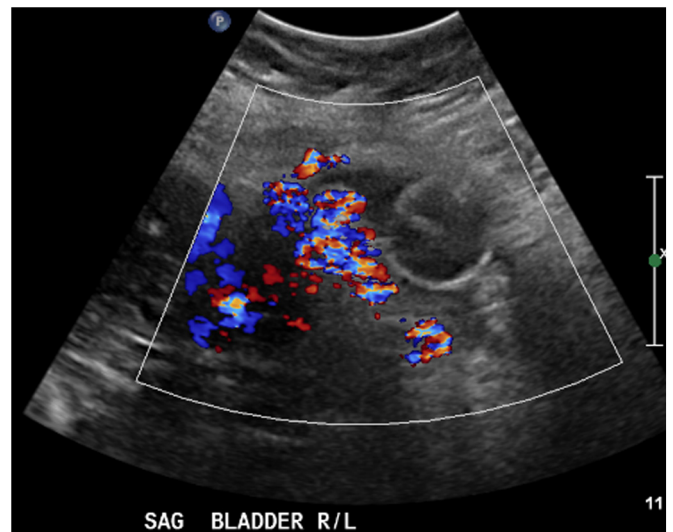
Color Doppler ultrasound at 24 wk gestation. Ultrasound demonstrates complete placenta previa with an enlarged placenta with prominent vascularity throughout the myometrium with loss of the retroplacental clear space, consistent with placenta accreta. The bladder is poorly distended during this examination; however, there does appear to be irregular soft tissue extending into the bladder near the dome and demonstration of several prominent vessels crossing from the anterior myometrium into the region of the bladder. Findings are highly suspect for placenta percreta with invasion into the bladder.
